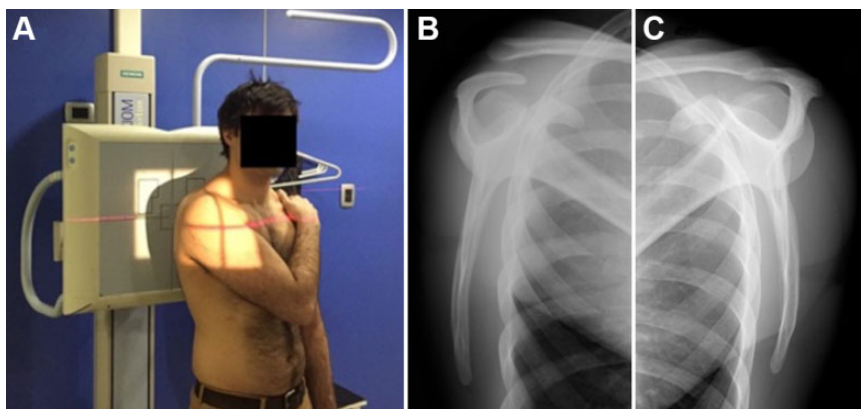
(A) Protocol for the modified Alexander radiographic view. The ipsilateral arm is placed in the cross-body position, increasing the load on the acromioclavicular joint. The patient is placed at a 45° angle to the detector for a Y-view of the shoulder. Subsequently, the scapula is parallel to the sagittal plane of the body and drawn away from the ribs in this posture. The modified Alexander view of the (B) affected (right) shoulder and (C) unaffected (left) shoulder.
